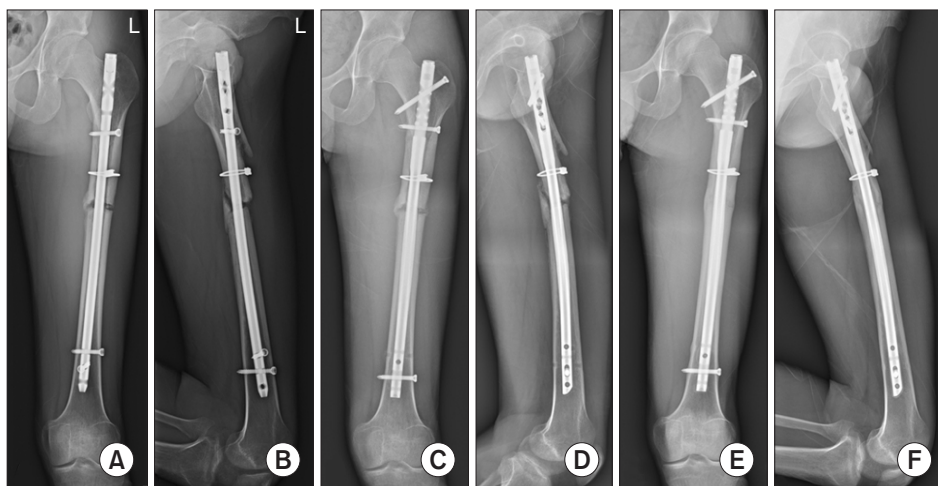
Femoral shaft nonunion in a 22-year-old male patient treated with exchange nailing via the dynamic mode. (A, B) Anteroposterior and lateral plain radiographs 8 months after the initial surgery revealed nonunion with a fracture gap and callus-to-diaphysis ratio of < 1.19 . (C, D) Postoperative radiographs after exchange nailing with the dynamic mode on the distal fragment. (E, F) Plain radiographs at 7 months after exchange nailing showing complete bone healing without apparent shortening.
